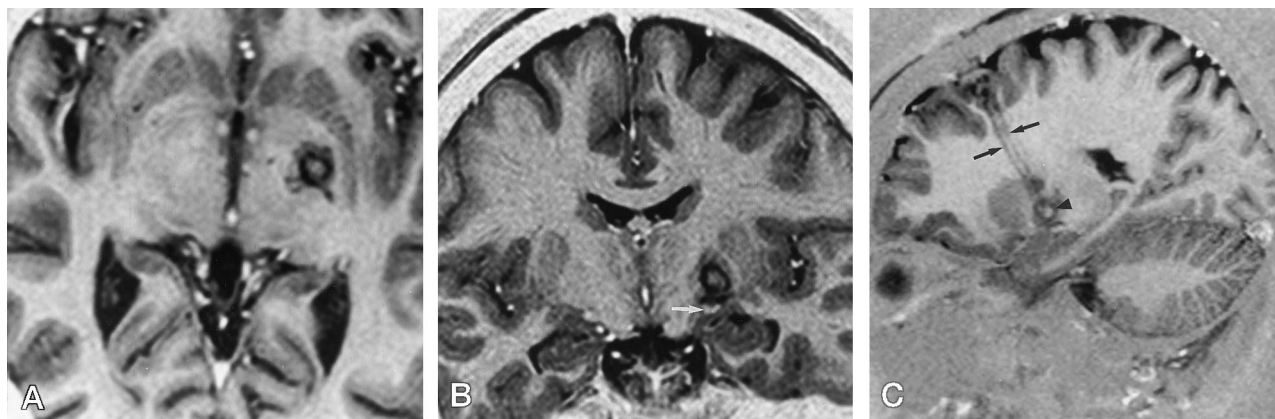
Turbo spin-echo IR (3000/40/4) MR images 24 hours after left-sided pallidotomy.
